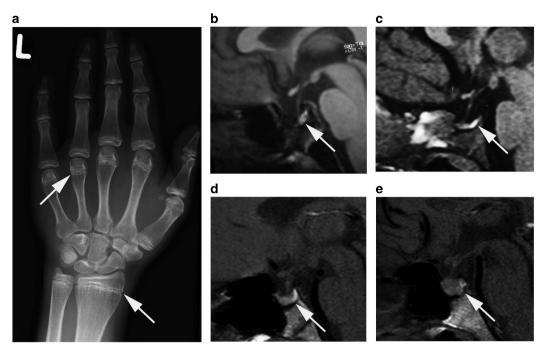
Imaging-based diagnostics of cases 2–4. (a) X-ray of the left hand of case 2 performed at the age of 40 years, demonstrating pronounced delay of skeletal maturation; arrow, epiphyseal cartilage with incomplete endochondral ossification. (b–e) Magnetic resonance imaging of the sella turcica of case 2 (b) and case 3 (c) demonstrate severe hypoplasia, whereas sagittal scans of individual IV/1 (d) and IV/6 of family 4 (e) show a nearly normal-sized and a slightly enlarged anterior lobe of the pituitary (arrows), respectively, but normal pituitary stalk and posterior lobe.
